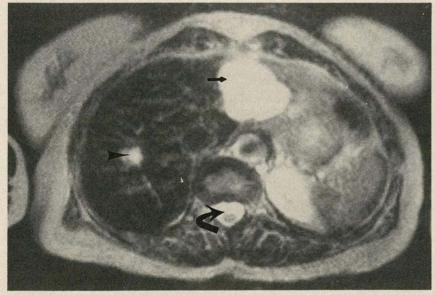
Axial T2-weighted image demonstrating large hemangioma in left hepatic lobe (straight arrow) and smaller hemangioma in right hepatic lobe (arrowhead). These lesions have signal similar to that of cerebrospinal fluid in subarachnoid space (curved arrow).
